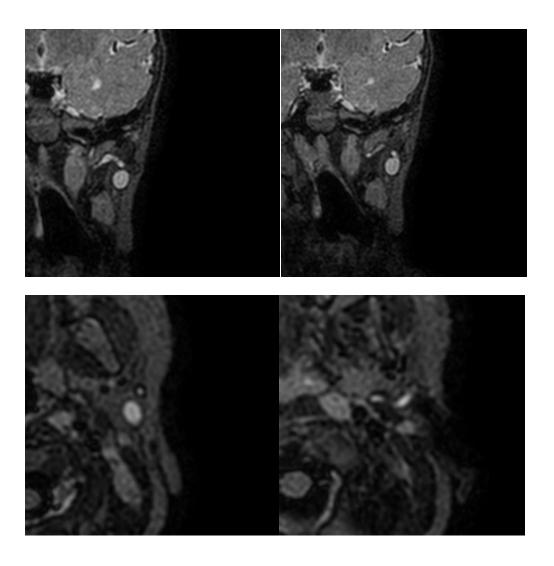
Coronal MPR (top left and right), Axial MPR (bottom left and right) MRI images for patient D. MRI showed a tract from the posterior aspect of the cheek toward the parotid gland communicating with a 10 x 7 x 9mm cyst (white arrow). Tract extended medially (white triangle) passing interior to the external acoustic canal and tapered in the left para-pharyngeal soft tissue.
